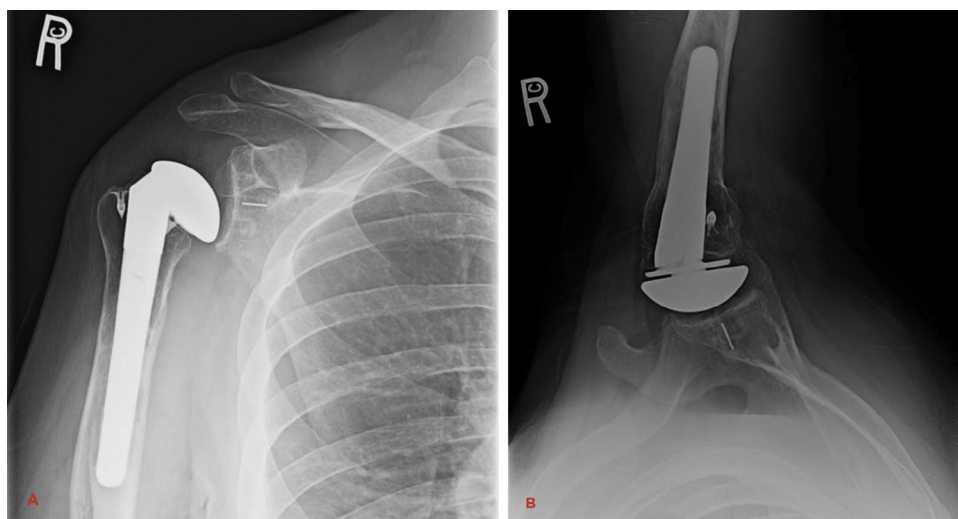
Preoperative anteroposterior (A) and axillary (B) radiographs.
